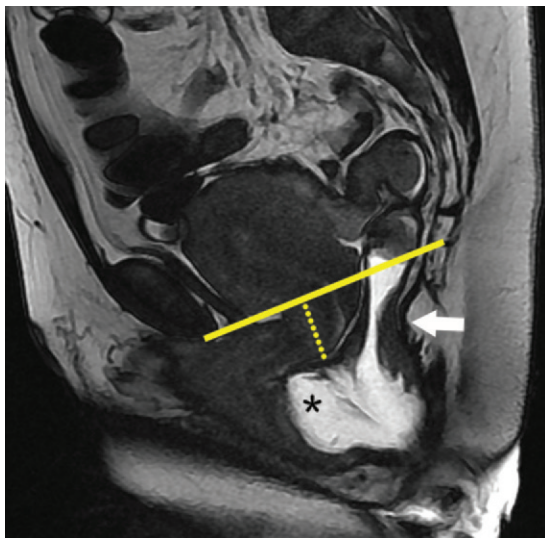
Pelvic organ prolapse in a 52-year-old woman with a bulging perineal mass. Sagittal FIESTA MR image obtained at maximal effort during defecation shows moderate uterine prolapse in the middle compartment (dotted line). In the posterior compartment, a moderate anterior rectocele (*) and caudal angulation of the levator plate (arrow) can be seen. Solid line = PCL.
